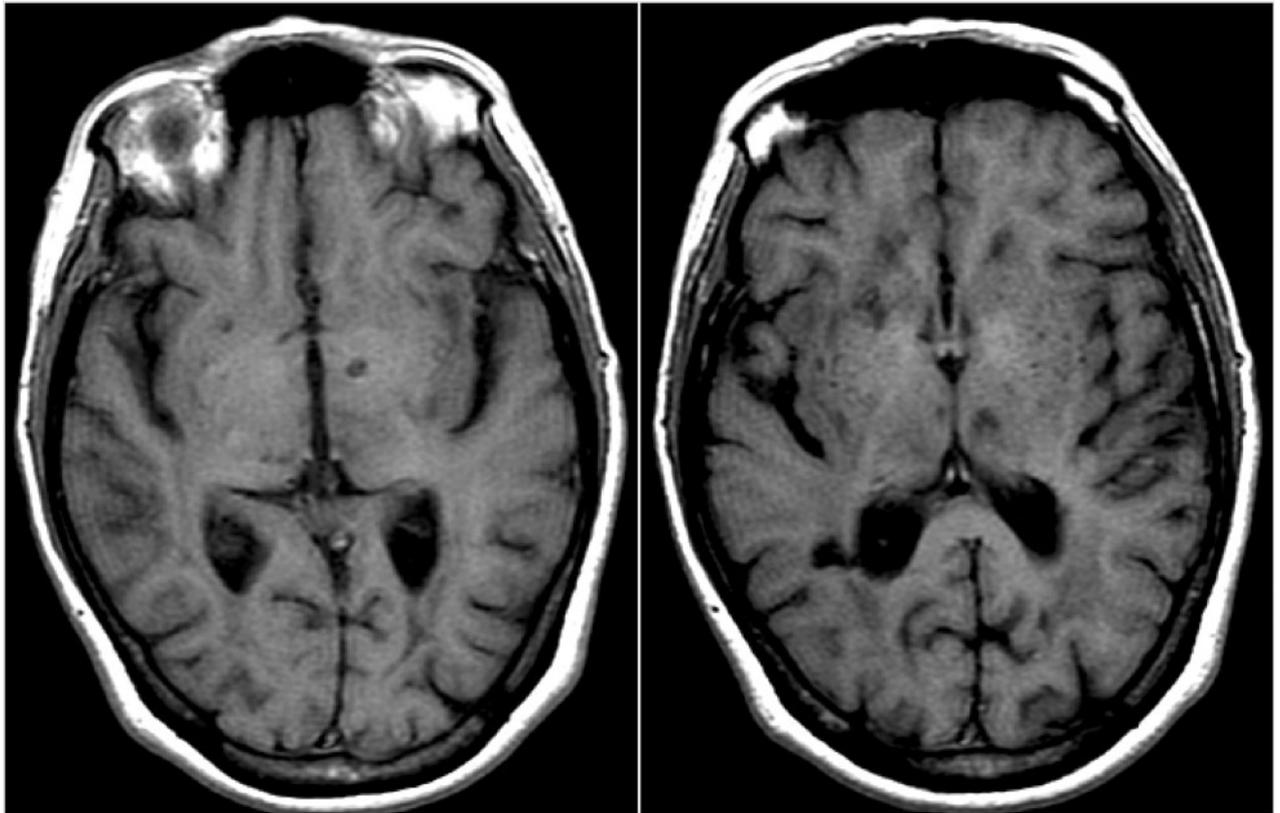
T1 weighted magnetic resonance image demonstrating multiple lacunar infarcts appearing as 'black holes'. Strategic infarcts involving both thalami are present
